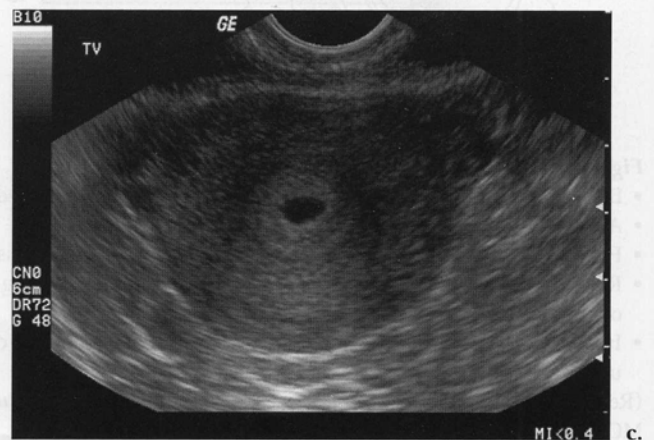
Transvaginal ultrasound of an early IUP, sagittal orientation. The transducer is placed in the vaginal vault and advanced until the uterus is seen (A). The indicator is positioned up to obtain a sagittal orientation (A). The normal anatomy of an early IUP (B). An ultrasound of a normal anteverted uterus with an early IUP is seen in sagittal orientation (C). (A is redrawn from Simon and Snoey, eds. *Ultrasound in Emergency and Ambulatory Medicine*. St. Louis, MO: Mosby-Year Book, 1997.)
